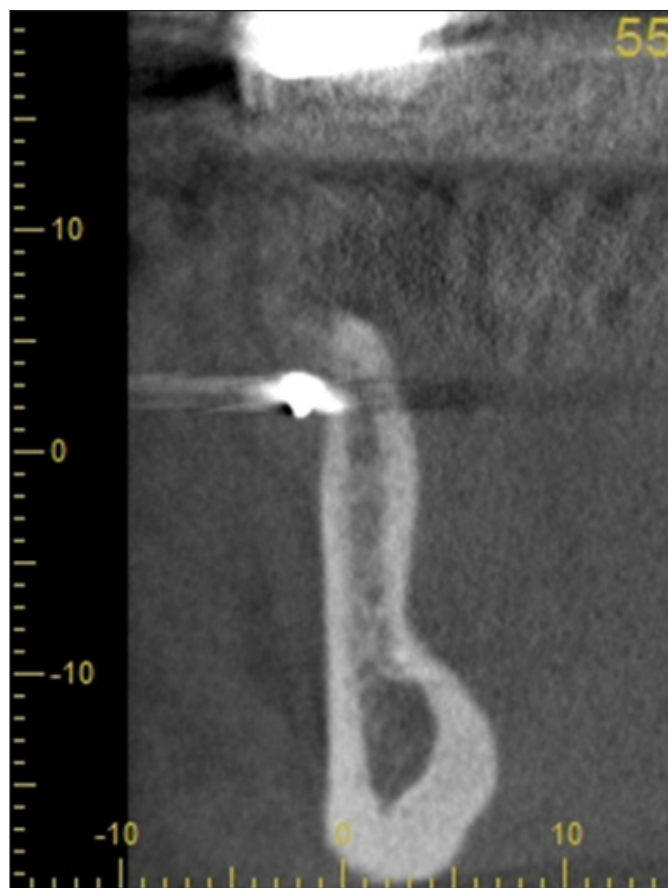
Preoperative CBCT image
